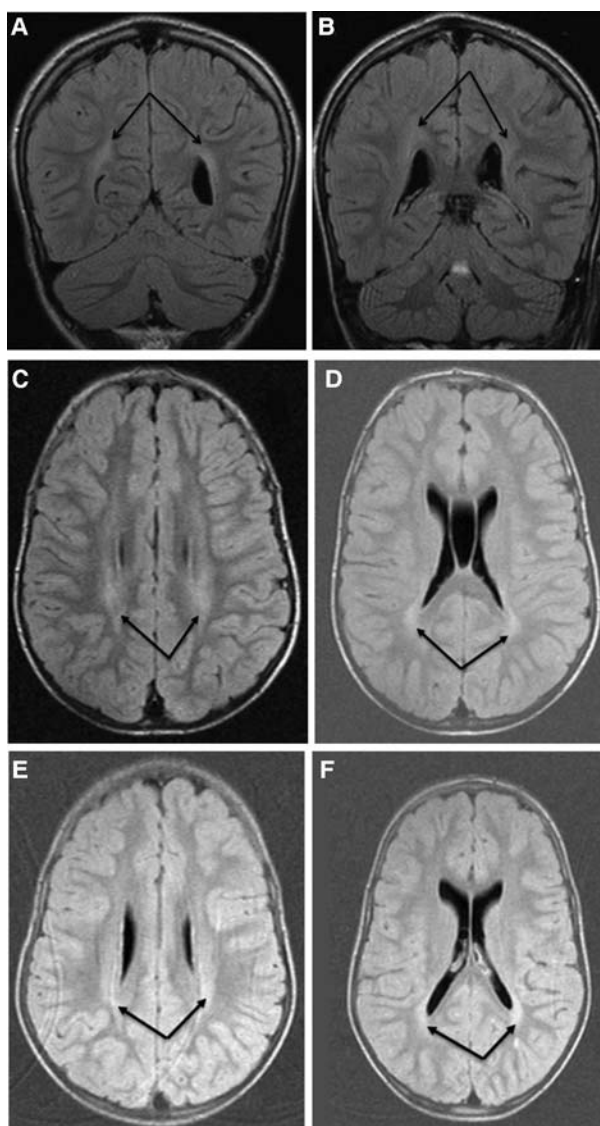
Coronal T2 fluid-attenuated inversion recovery (FLAIR) brain magnetic resonance imaging (MRI) images of Patient 1 (A,B) and axial T2 FLAIR brain MRI images of Patients 2 (C,D) and 3 (E,F) showing hyperintense periventricular white matter lesions, especially in parieto-occipital regions.
